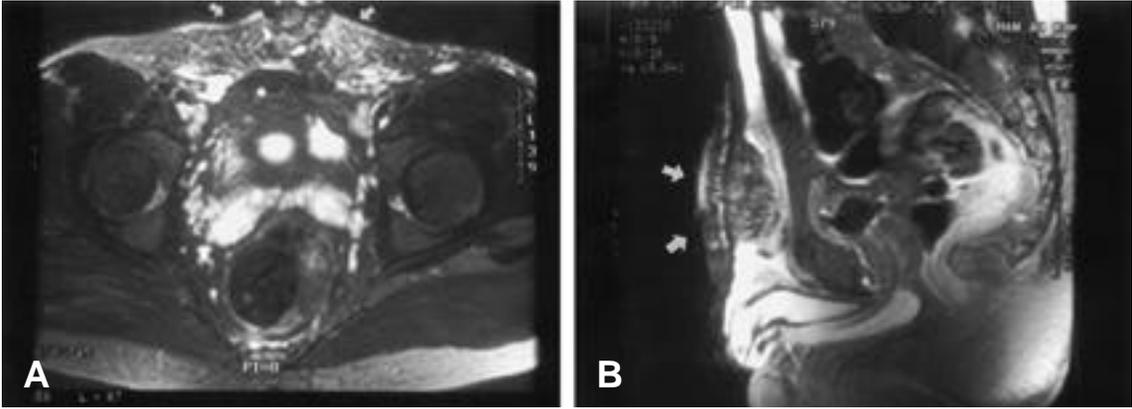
Axial(A) and sagittal(B) MR images show the heterogeneous high signal mass, infiltrating rectus abdominis in T2W image.
